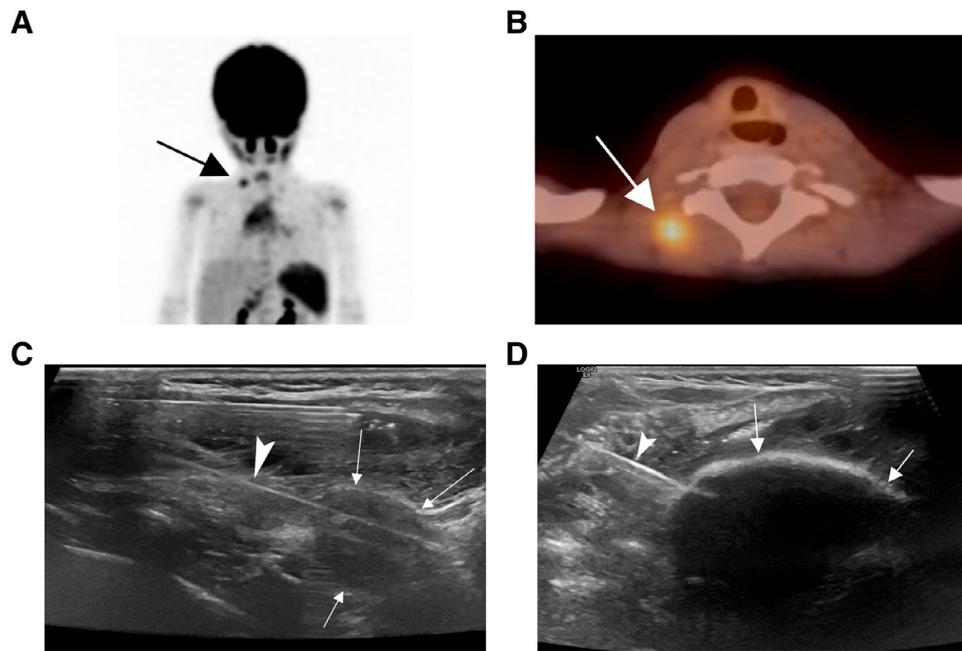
3-year-old male with history of stage III embryonal rhabdomyosarcoma of the thorax (at 1 year of age). PET/CT coronal MIP (A) and axial fusion (B) images demonstrates tumor recurrence with a single hypermetabolic nodule (arrow) in the right posterior neck soft tissues, overlying the trapezius muscle. Local control of the nodule with cryoablation under ultrasound guidance. Image C shows nodule (arrows) localization with placement of the cryoprobe (arrowhead). Image D shows post ablation with a well-formed ice-ball (arrows) completely encapsulating the nodule. MIP, maximum intensity projection; PET/CT, positron emission tomography/computed tomography. (Images used with permission of Dr. Abhay 'Finn' Srinivasan).
